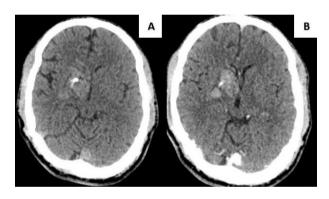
Preoperative cranial CT scan demonstrates a mildly hyperdense irregular lesion in the right basal ganglia with dense calcification (A) and a heterogenous, moderate enhancement in the postcontrast study (B).
